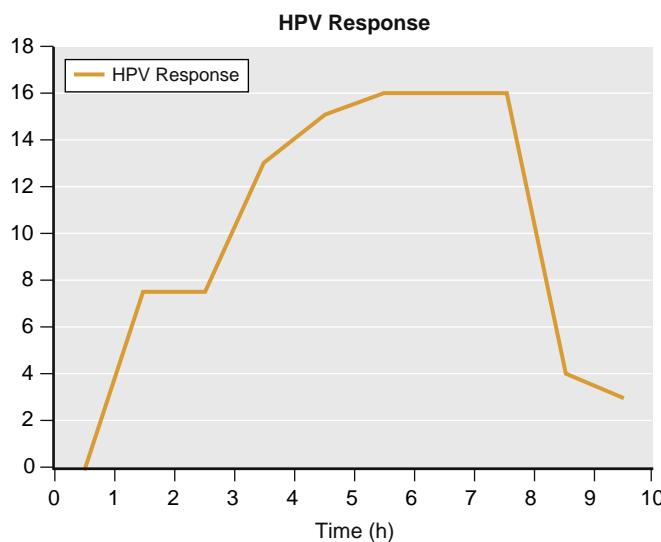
The relationship between hypoxic pulmonary vasoconstriction (HPV) (vertical axis) and time in hours (h) (horizontal axis) in humans exposed to isocapnic hypoxia (approximate inspired PO_2 60 mm Hg) beginning at baseline with a return to normoxia at 8 hours. HPV response was measured as the increase in echocardiographic right ventricular systolic pressure. Note the two-phase, rapid and slow, onset of HPV. Also note that after prolonged HPV, the pulmonary pressures do not return to baseline for several hours. (Based on data from Talbot, et al. *J Appl Physiol*. 2005;98:1125.)
